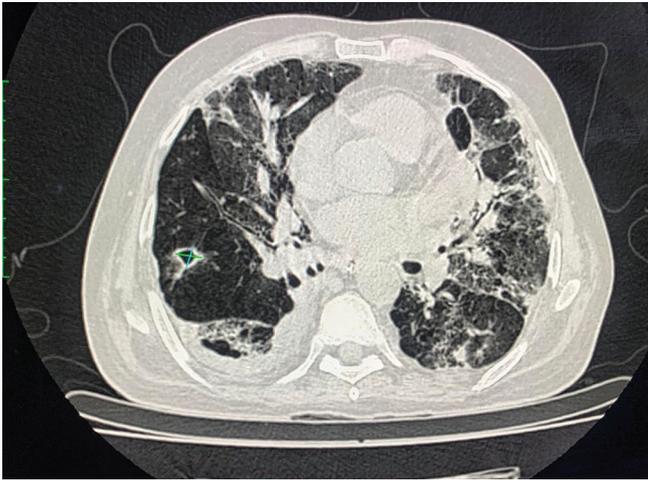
HRCT thorax showing cavitory lesion in enlarged view with green cross
